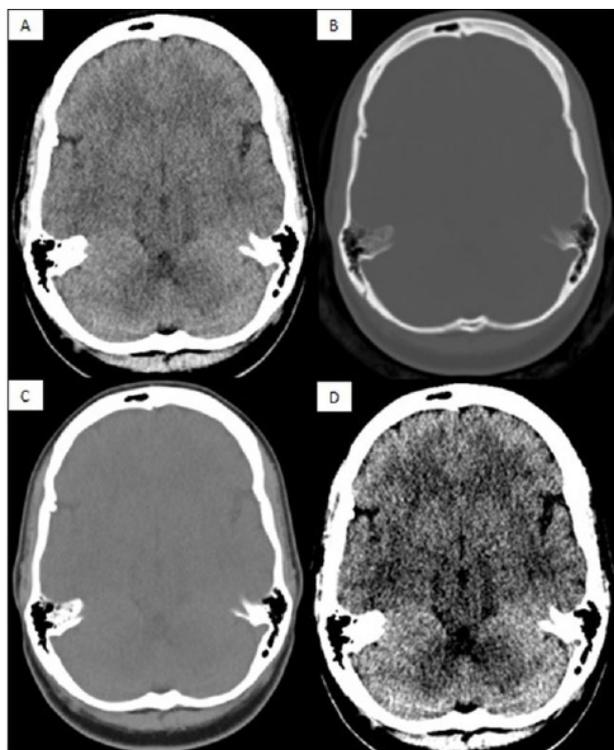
Common window settings used when interpreting a normal CT Brain scan. A: Brain window (WW 80, WL 40); B: Bone window (WW 3000, WL 500); C: Soft tissue window (WW 260, WL 80); D: Stroke window (WW 40, WL 40).
